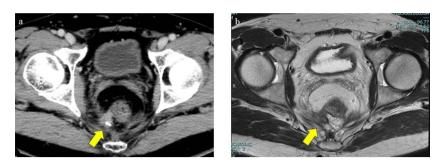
CT, magnetic resonance imaging (MRI), and positron emission tomography (PET)-CT show a recurrent tumor of 30 mm in size on the dorsal surface (arrows). (a) CT, sagittal plane. (b) Fat-suppressed T2-weighted MRI, sagittal plane. (c) PET-CT, axial plane. (d) T2-weighted MRI, axial plane.
